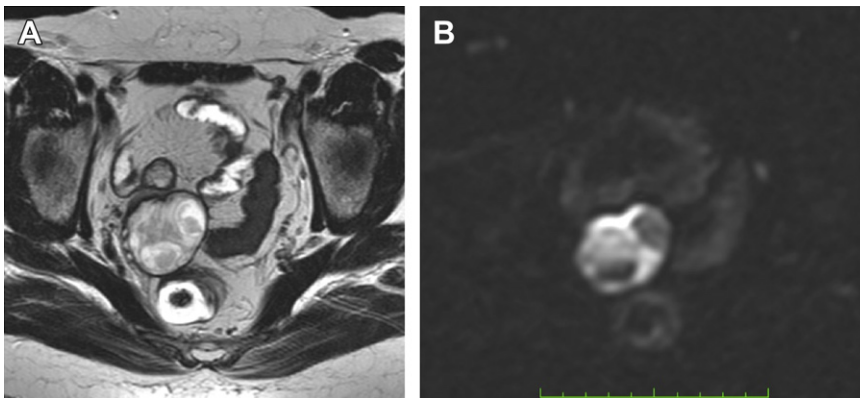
Ovary edema. Axial T2-weighted image shows enlarged edematous right ovary with peripheral follicles. DWI shows restricted diffusion. (A) Axial T2-weighted image. (B) DWI.
